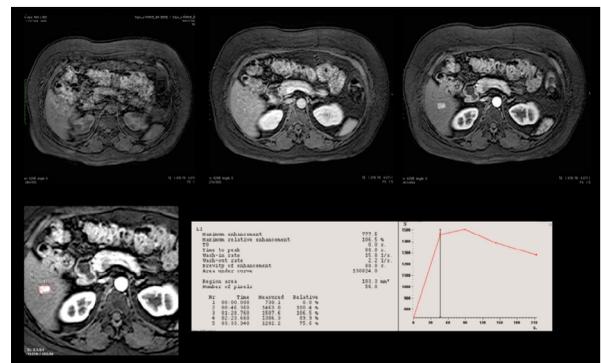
Adenoma: (46 years old, female) A-TSE T2A, B- DWI b 1000, C, D, E- Time-intensity curve and semiquantitative analysis values of the lesion in the arterial phase and the whole lesion in the dynamic series
